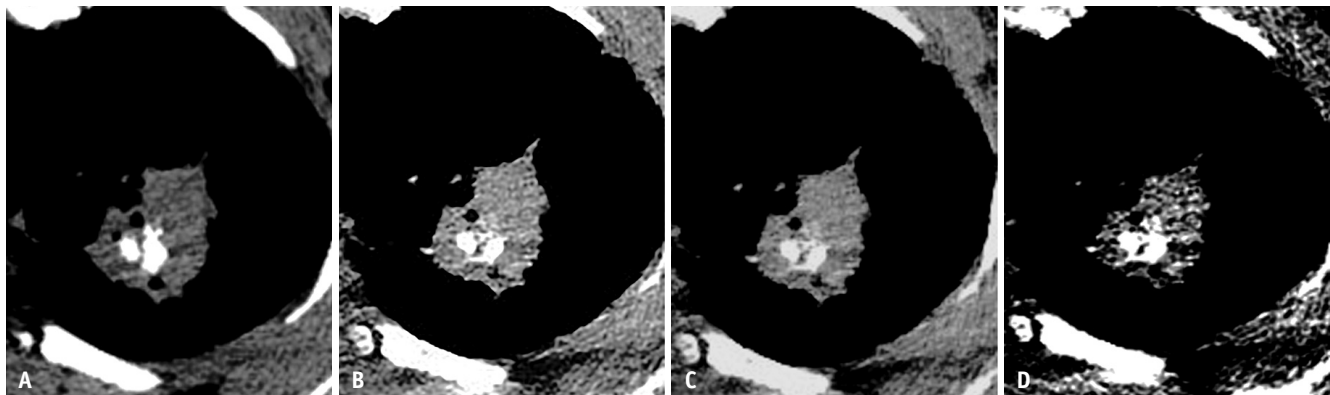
CT images of multiple calcifications in lobular consolidation shown in the mediastinal window of the standard dose CT iDose (A) and ULDCCT reconstructed with GAN, iterative model reconstruction, and iDose (B-D).
